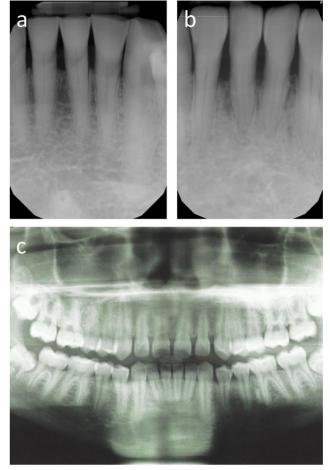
Preoperative periapical and panoramic radiographs: 3a Case 1. 3b Case 2. 3c Case 3.
